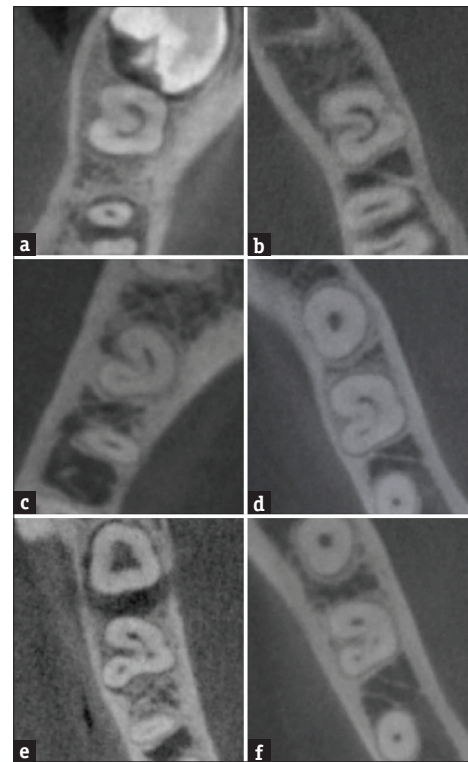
Example of different axial CBCT sections for mandibular second molars middle level shows: type C1 (a and b); type C2 (c and d); and type C3 s (e and f)
